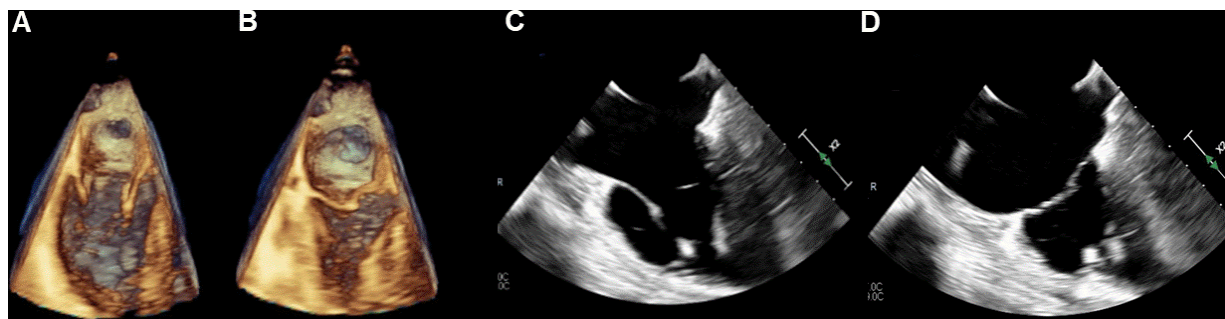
Echocardiographic assessment of an 83-year-old patient with a dilated right ventricle with systolic dysfunction. Three-dimensional echocardiography demonstrates the right ventricle during diastole (A) and systole (B). Transoesophageal echocardiography of the same patient demonstrates right ventricular structure during diastole (C) and systole (D).
